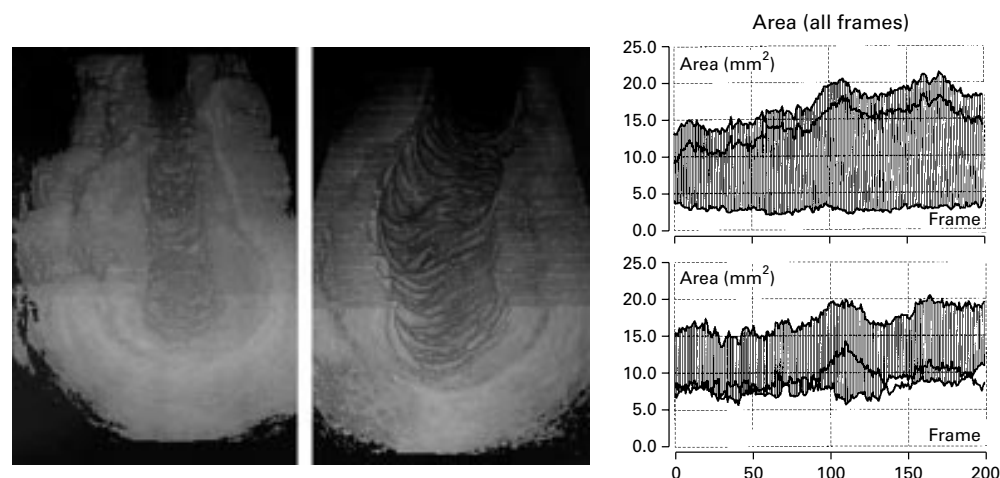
Lesion before and after balloon optimised directional atherectomy. Spatial (three dimensional) views (left and mid panel) are reconstructed from the complete intravascular ultrasound datasets which are used for volumetric analysis, underlining the high spatial resolution of the volumetric measurements in this study. The right panel shows the cross sectional area measurements both before (upper panel) and after the intervention (lower panel). Linear functions of the vessel and lumen cross sectional area form the upper and lower boundaries of the greyish area, which represents the plaque cross sectional area measurements from distal (left) to proximal (right). Alternatively, values of the plaque cross sectional area can be derived directly from a linear function (single black line), which here mostly overlaps the greyish area. Note, that in this example, both plaque ablation and vessel expansion contributed to the increase in lumen volume.
